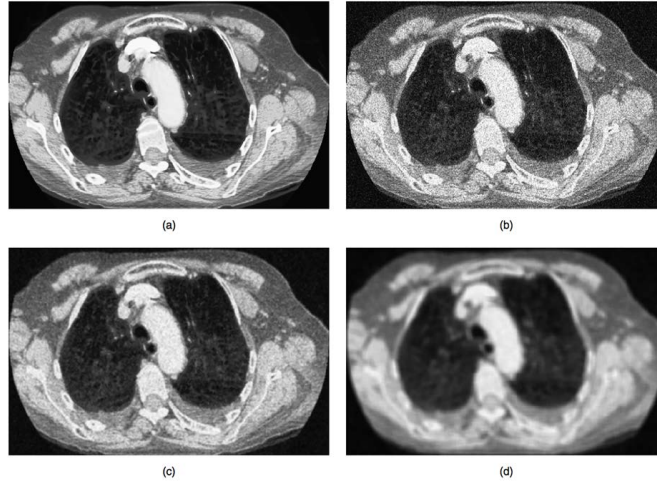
(a) Original CT image. (b) Original image in (a) corrupted by added Gaussian white noise with maximum amplitude of ± 25 gray levels. (c) Image in (b) convolved with the 3×3 mean filter. The mean filter clearly removes some of the additive noise; however, significant blurring also occurs. This image would not have significant clinical value. (d) Image in (b) convolved with the 9×9 mean filter. This filter has removed almost all the effects of the additive noise (Courtesy of Ms. Bonnie Cameron, MRT and Dr. Paul Schulte, Regina General Hospital) Bankman (2008).
